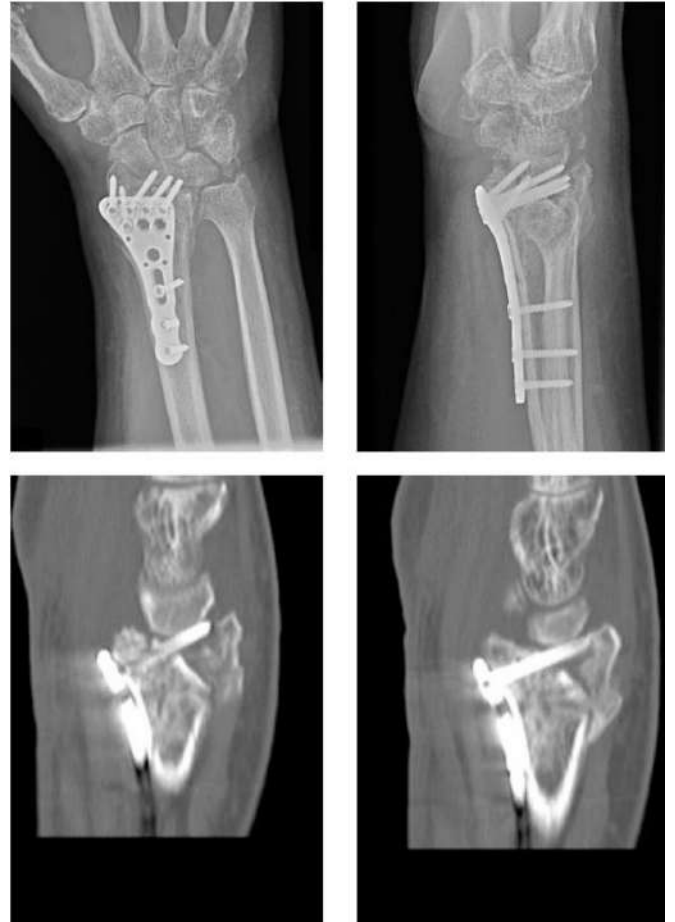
Intraarticular prominence of a distal screw line, X-ray projection AP and side (upper images), CT in sagittal incisions (bottom images)
